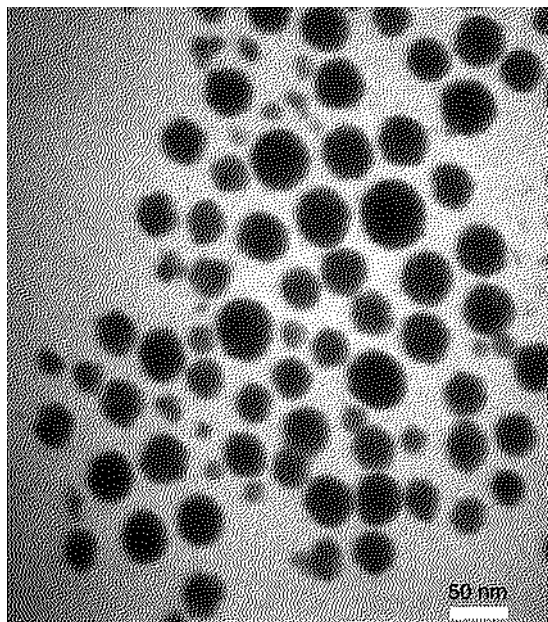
TEM image of basil oil nanoemulsion. Reprinted with permission from [Ghosh et al. \(2013\)](#). Ultrasonic emulsification of food-grade nanoemulsion formulation and evaluation of its bactericidal activity. *Ultrason. Sonochem.* 20, 338–344.
